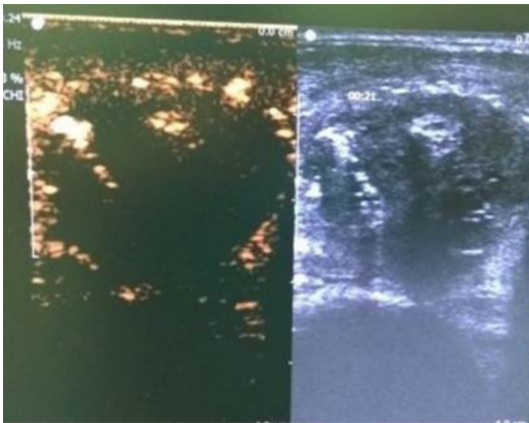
Ultrasonographic features after MWA. The nodule was completely ablated and no contrast agent filled this region.
